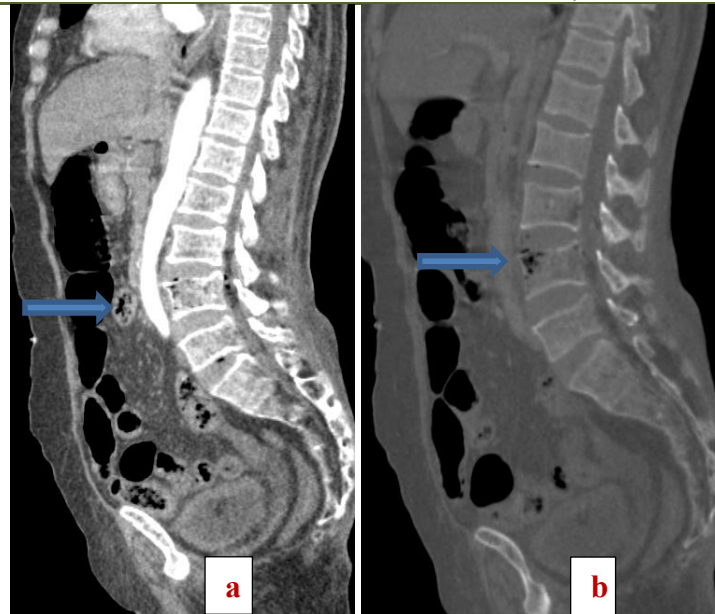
Abdominal CT in parenchymal (a) and bone windows (b) showing the L4 vertebral body containing air bubbles (arrow) extending into the spinal canal and the L3–L4 intervertebral disc, associated with subtle cortical bone disruption
